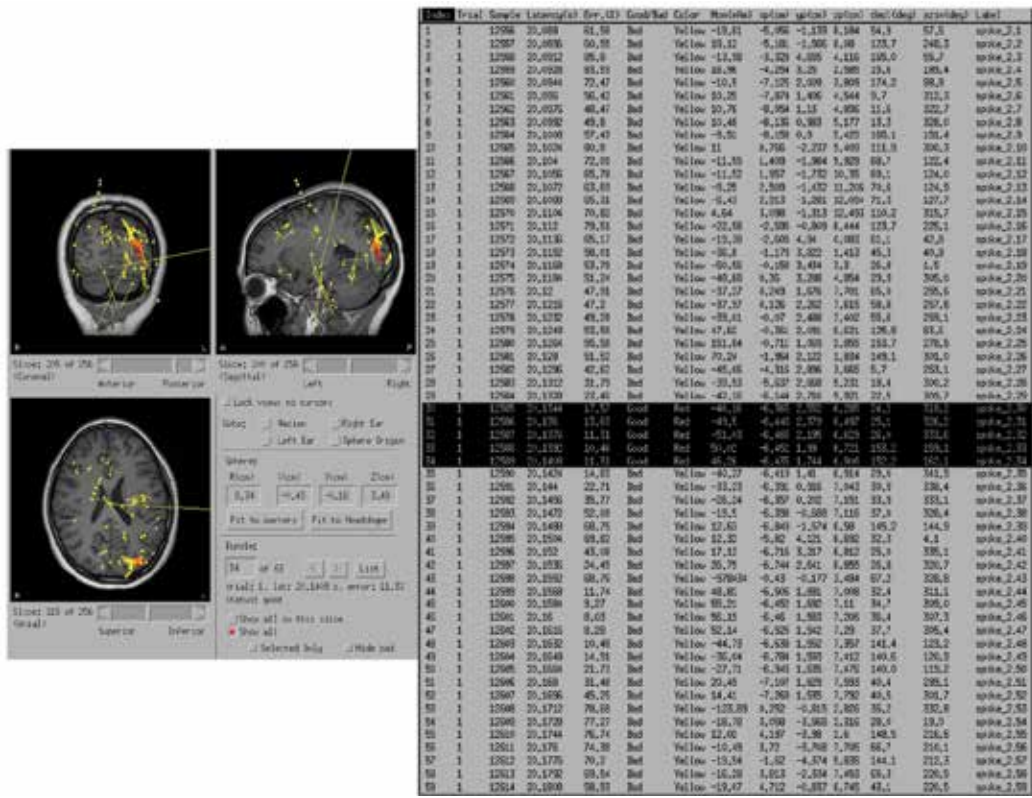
Stability of dipole locations. Left panel shows coronal (left top), sagittal (right top) and axial MRI. Before selection of MEG dipoles by criteria (Table 1), all calculated MEG dipoles in one dataset (two minutes) are shown on transparent MRI. Right table shows information of all MEG dipoles from one spike before selection by the criteria described in Table 1 (latency, residual error, amplitude, x-, y-, z-axes, and angle of moment). To select one dipole from one spike (total 63 time points by sampling rate 625 Hz), dipole locations (red circles on MRI) of consecutive 5-6 time points (right, black highlights on the list) stay within 1cm on x-, y-, z-axes and/or within one gyrus.
